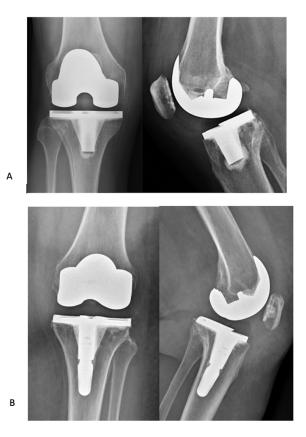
Post-operative X-rays of both implants with same mediolateral size showing the differences between the keel (shape and length) with and without stubby stem.
